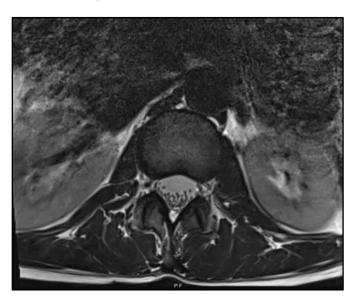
Axial view of MRI lumbar spine without contrast, T2 view in 2023.
